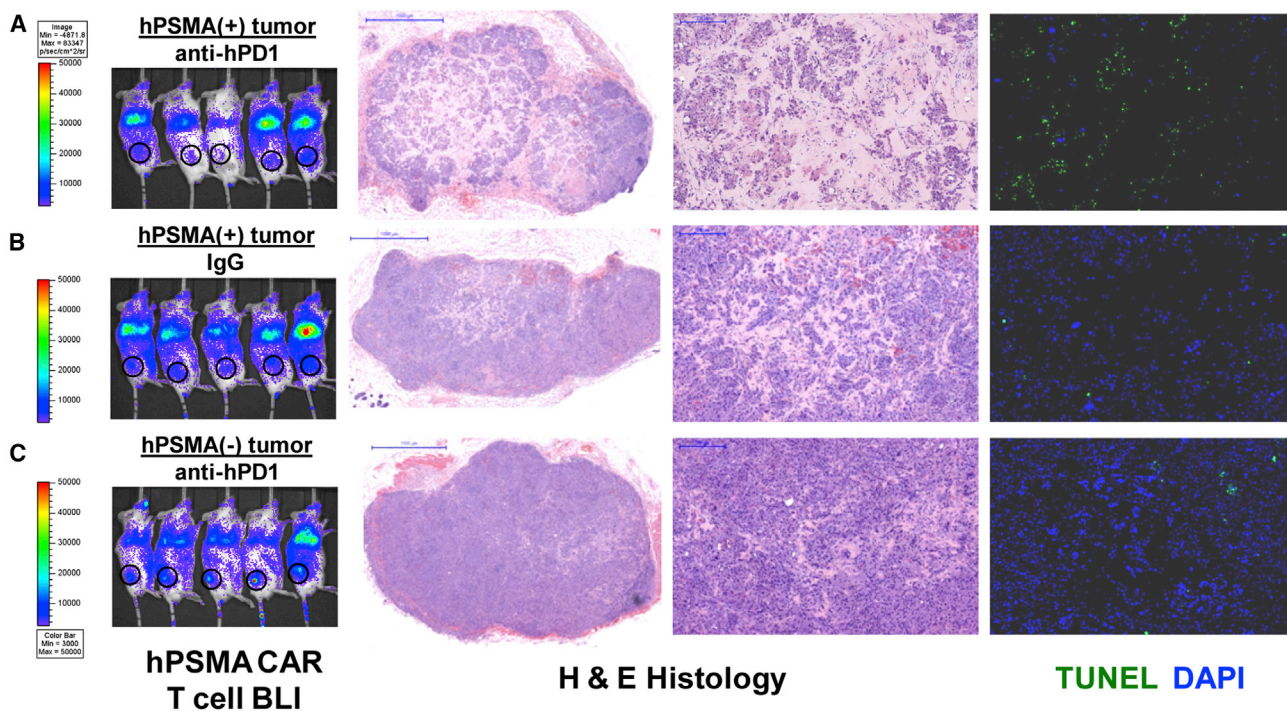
Distribution of Anti-hPSMA CAR T Cells at 24 hr and Analyses of Tumor Treatment Response
